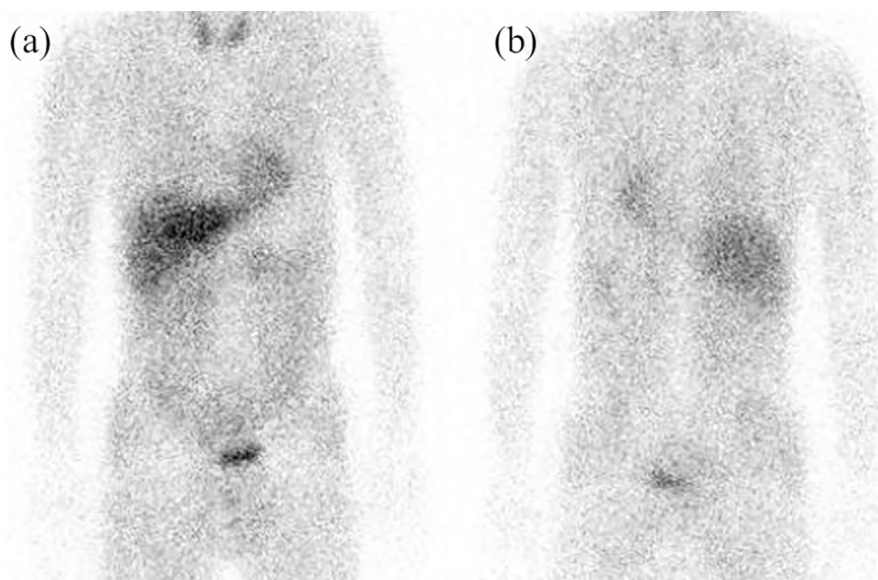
Iodine-123 adrenal MIBG scintigraphy findings. Iodine-123 adrenal MIBG scintigraphy showed no increase in the uptake of this tumor. a: Anterior, b: Posterior.
